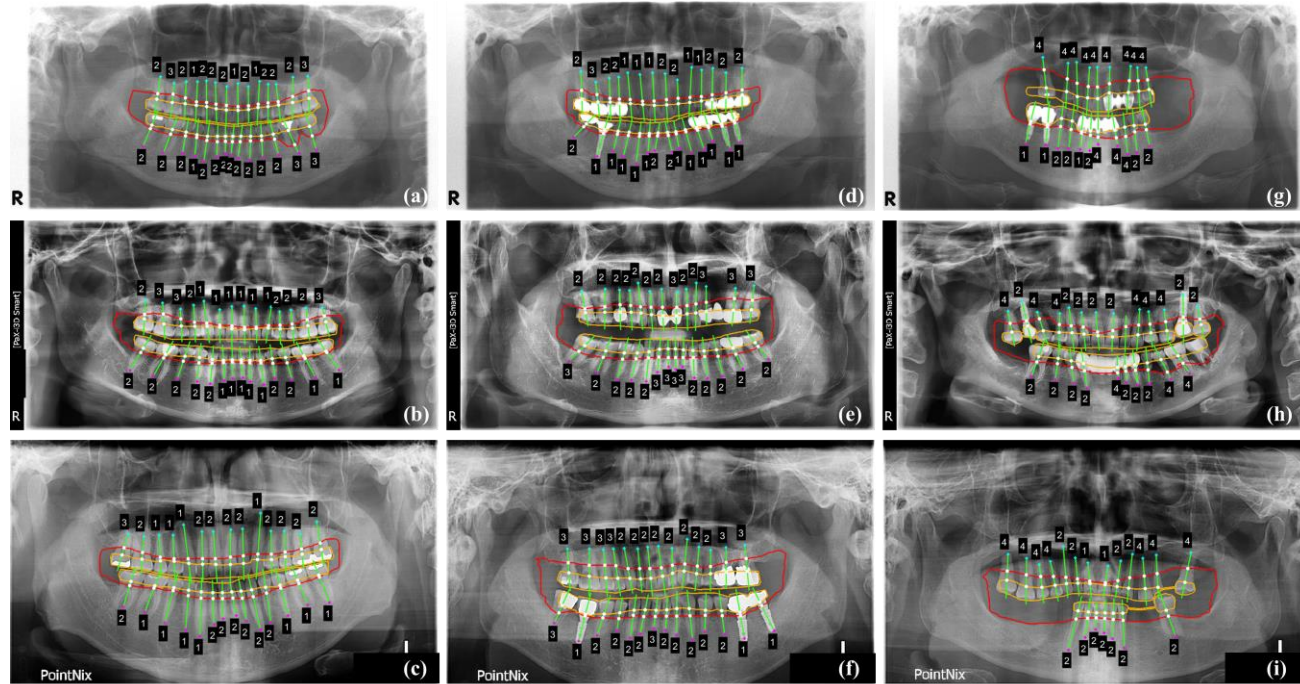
The stages of the periodontitis for each tooth and implant on the dental panoramic radiographs acquired from multiple devices. The automatic diagnosis results by the developed method on the images. The first, second, and third rows are the images from the device 1, device 2, and device 3, respectively.
